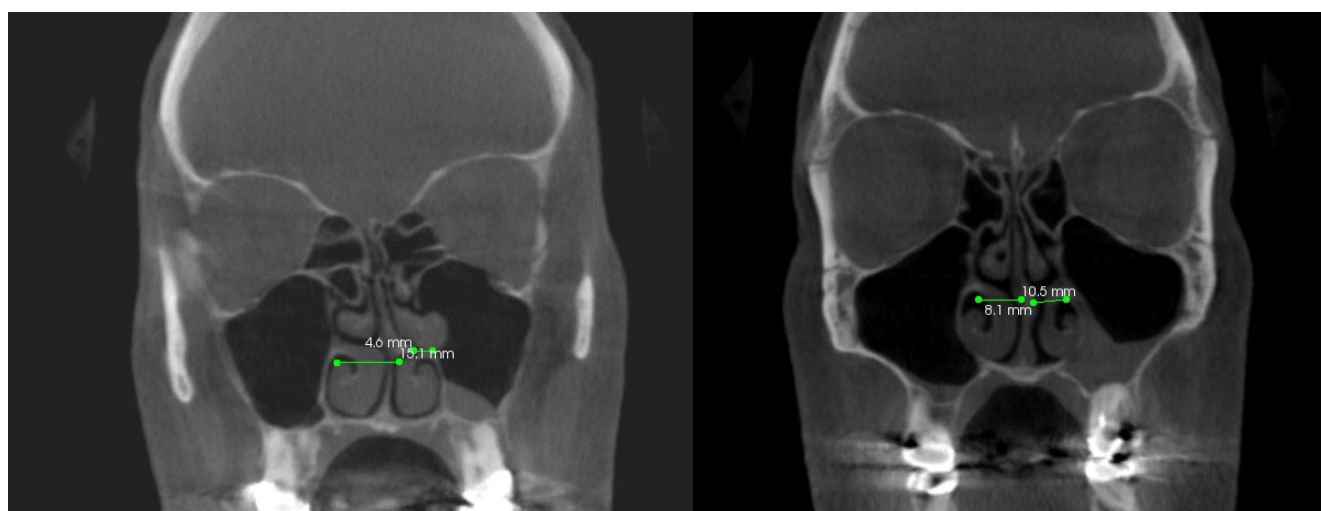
Pre-operative and post-operative coronal CT shows septal deviation at PMD. Pre-operative (left) CT shows septal deviation, while post-operative (right). Coronal CT images demonstrating preoperative (left) and postoperative (right) measurements at the point of maximal deviation (PMD). All measurements were obtained at a consistent anatomic level using a fixed reference point at the tip of the nasal spine or cartilage tip of the nose. Values were converted to ratios, with 1.00 indicating perfect midline symmetry, to allow for direct comparison between time points. CT demonstrates a 38% improvement in alignment after CNB-assisted septoplasty.
